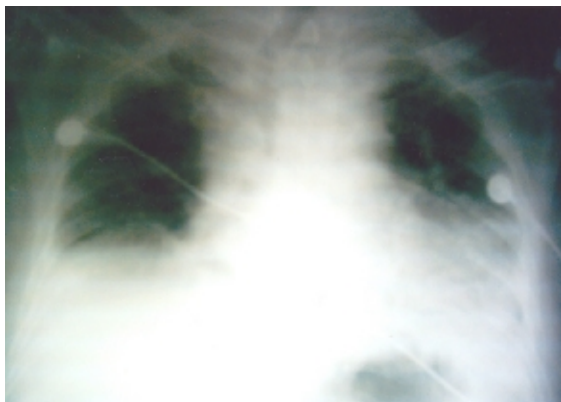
Bilateral pleural effusion and diffused infiltration in the chest radiograph 2 hours after operation.
